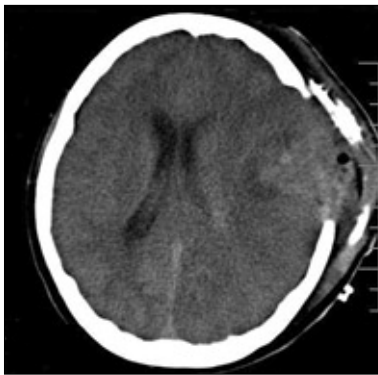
Postoperative cerebral magnetic resonance image shows the removal of the tumor via left frontoparietotemporal craniotomy, postoperative changes and decrease of subfalcine herniation towards the right.
